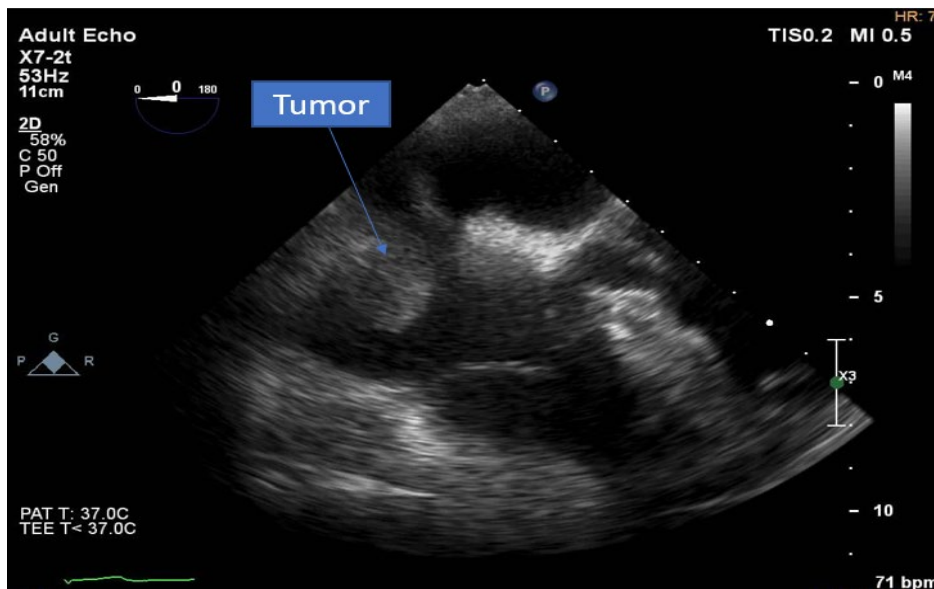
Intracardiac tumor, Transesophageal echocardiography
